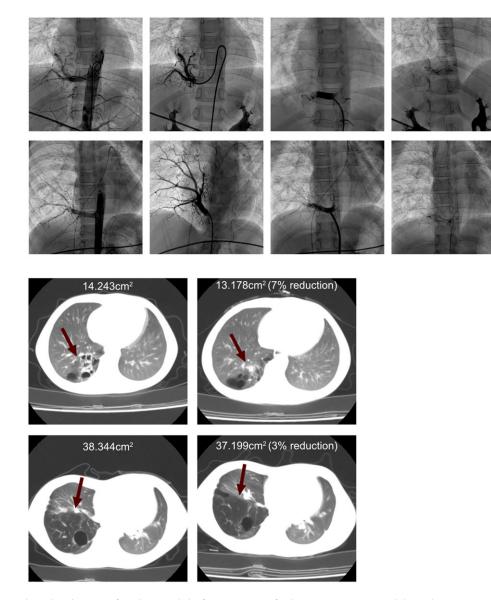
The angiography and implantation of Amplazter occluder for two patients of pulmonary sequestration with large aberrant systemic artery (*a* for patient 1, and *b* for patient 2). CT scanning demonstrated the lesions of lungs before and after occlusion (*c* for patient 1 before occlusion, *d* for patient 1 after 2-year-follow-up post occlusion); *e* for patient 1 before occlusion, *f* for patient 1 after 2-year-follow-up post occlusion). The follow-up results demonstrated the large residual lesions after Amplatzer occluder implantation for a large aberrant artery supplying pulmonary sequestration.
